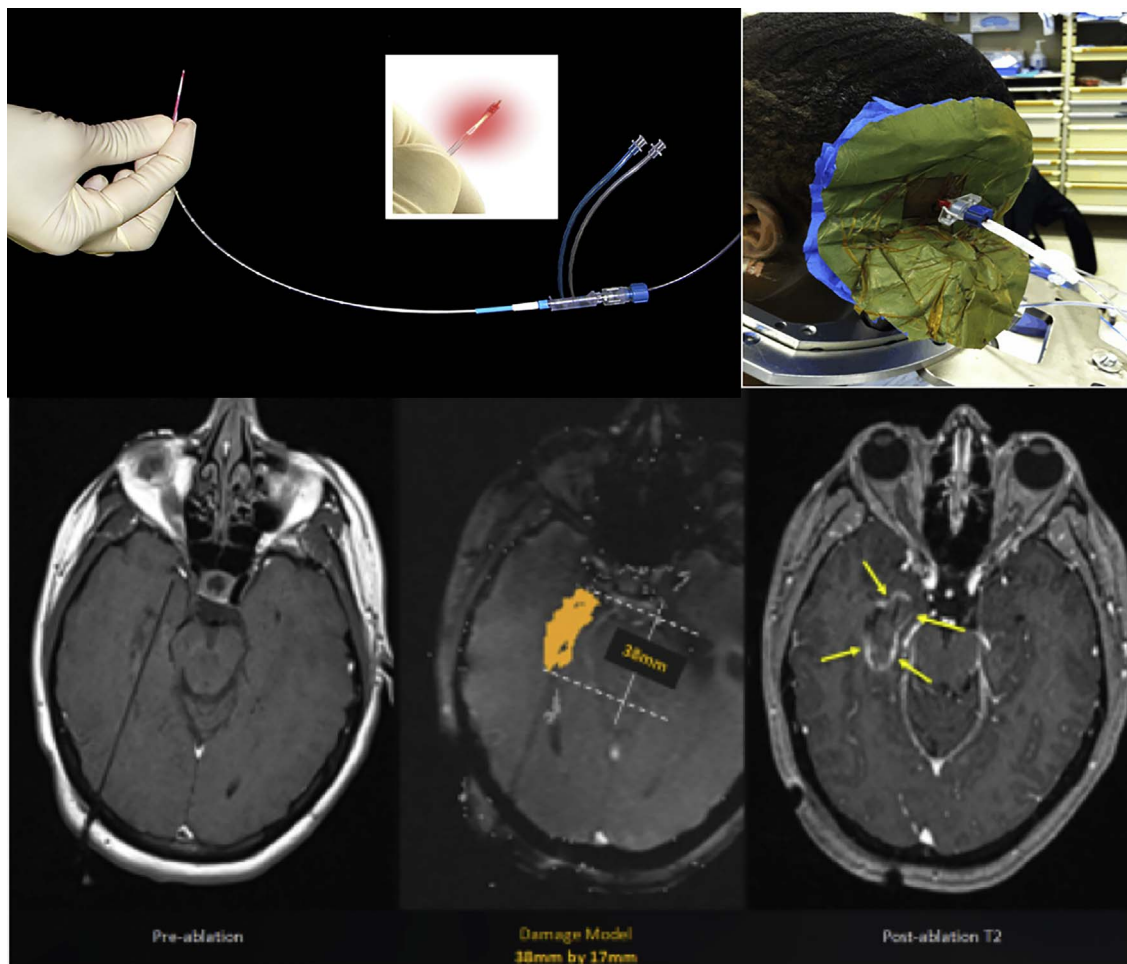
Depiction of the Optical Fiber, the Ablation Process, and Pre- and Post-Ablation MRI Images in an Axial Plane Demonstrating the Focal Nature of the Damage Zone.
